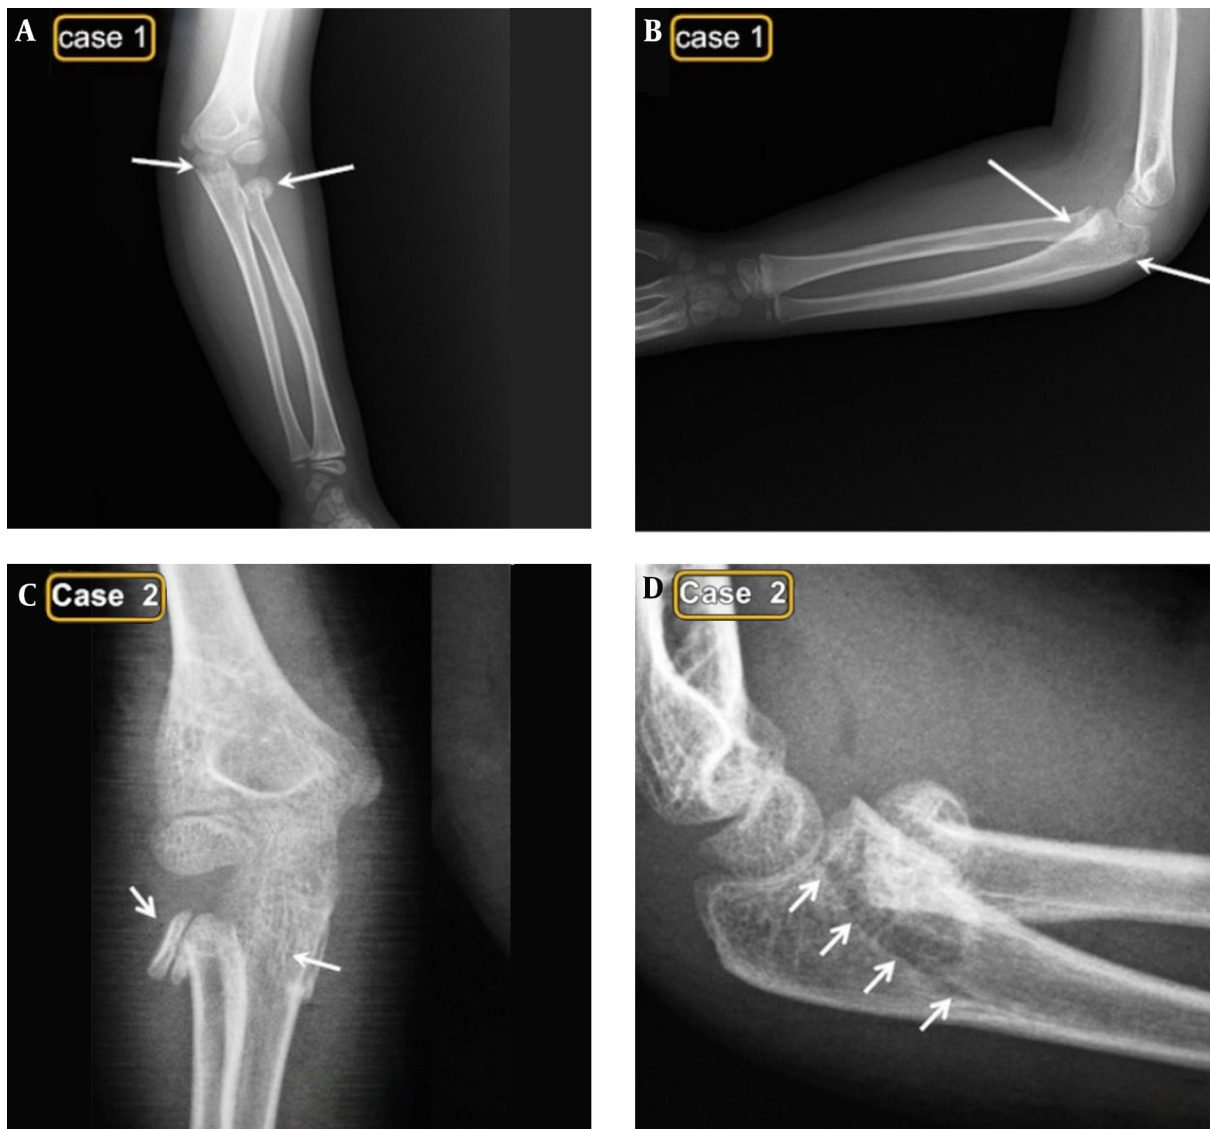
Pre-Operative Radiographic Appearance. Arrows show lateral displacement of radial head and non-displaced fractured olecranon in anteroposterior and lateral view. Notice that proximal radio-ular diastasis did not exist in both cases.
